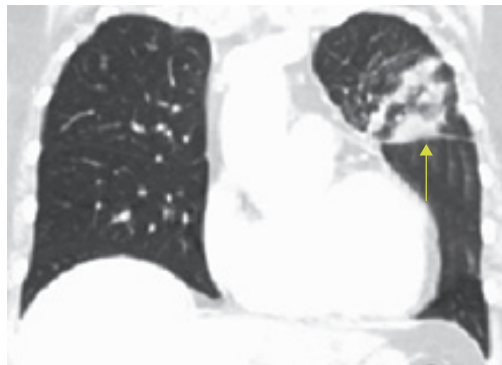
CT after two cycles of chemotherapy. The arrow indicates the primary tumour. Image from August 2018.
